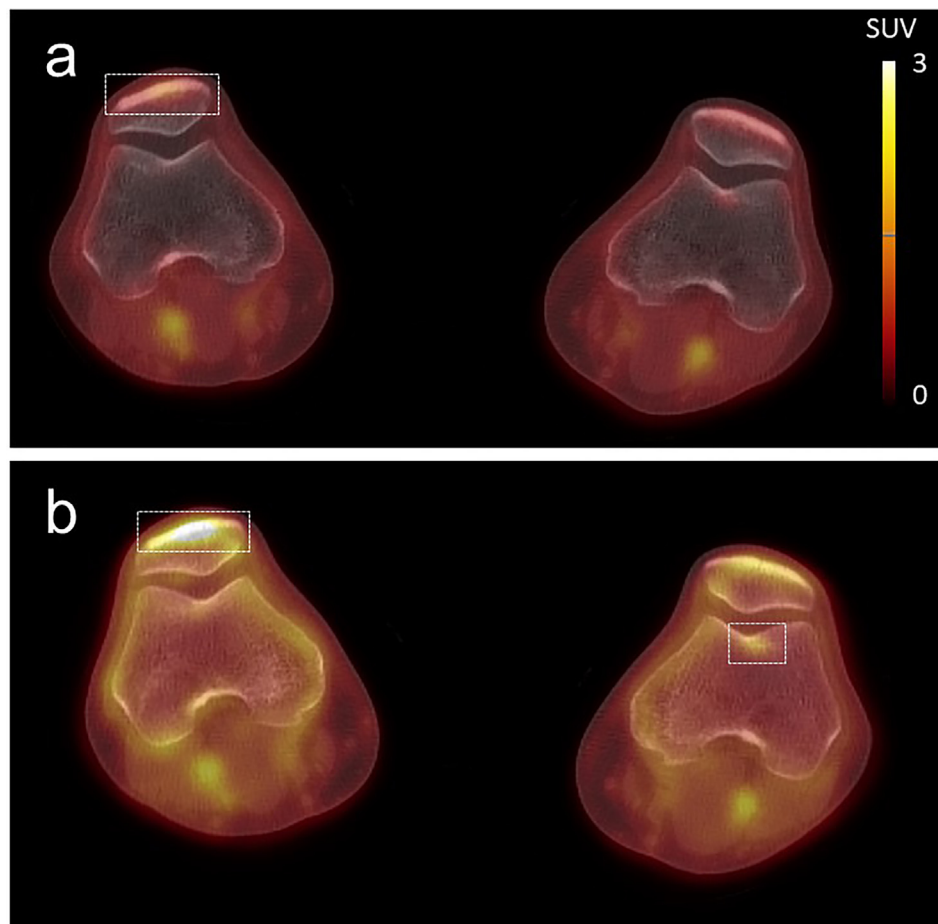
Representative axial Na^[18F]F PET images of the femur and patella at rest (a) and after knee loading (b). The images display higher SUV values in the patella of the pain-free knee (right knee, left side of image) compared to the painful knee (right side of image), as well as a localized area of increased SUV in the trochlea of the painful knee after exercise. The scale bar denotes SUV values, and the dashed squares indicate focal areas of increased SUV.
